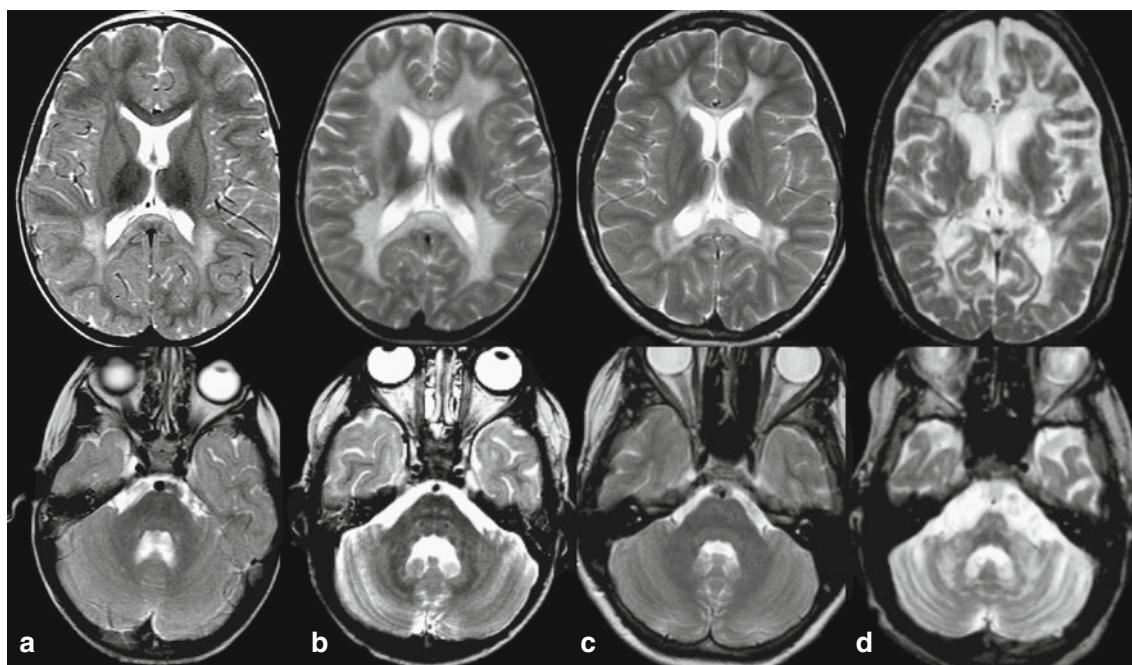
Example T2-weighted axial MR images of patients with late-infantile MLD in the early (a) and late (b) phase and with juvenile MLD in the early (c) and late (d) phase of the disease. a) 2 years 4 months old girl, who had presented with first symptoms one month prior to the MR scan. MRI shows the typical pattern of severe parieto-occipital WM hyperintensity of periventricular and central WM, sparing subcortical WM (already myelinated). In the frontal WM only central parts are slightly involved. Both genu and splenium show signal hyperintensities, with the splenium more severely affected. Internal capsule is not yet involved, neither are there signs of cerebral atrophy or cerebellar involvement yet. b) 3 year-old girl, 23 months after first symptoms. Note the severe centrifugal spread of WM signal hyperintensities, involving partly subcortical areas and the corpus
